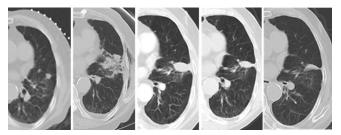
Patient with biopsy proven primary squamous cell carcinoma. At 1 and 2 years postprocedure, complete response maintained without evidence of recurrence. 85% decrease in longest diameter at 2.5 years when compared with initial postprocedure computed tomography. From left to right: Preradiofrequency ablation, immediate postprocedure, 3 months, 12 months, 2.5 years
